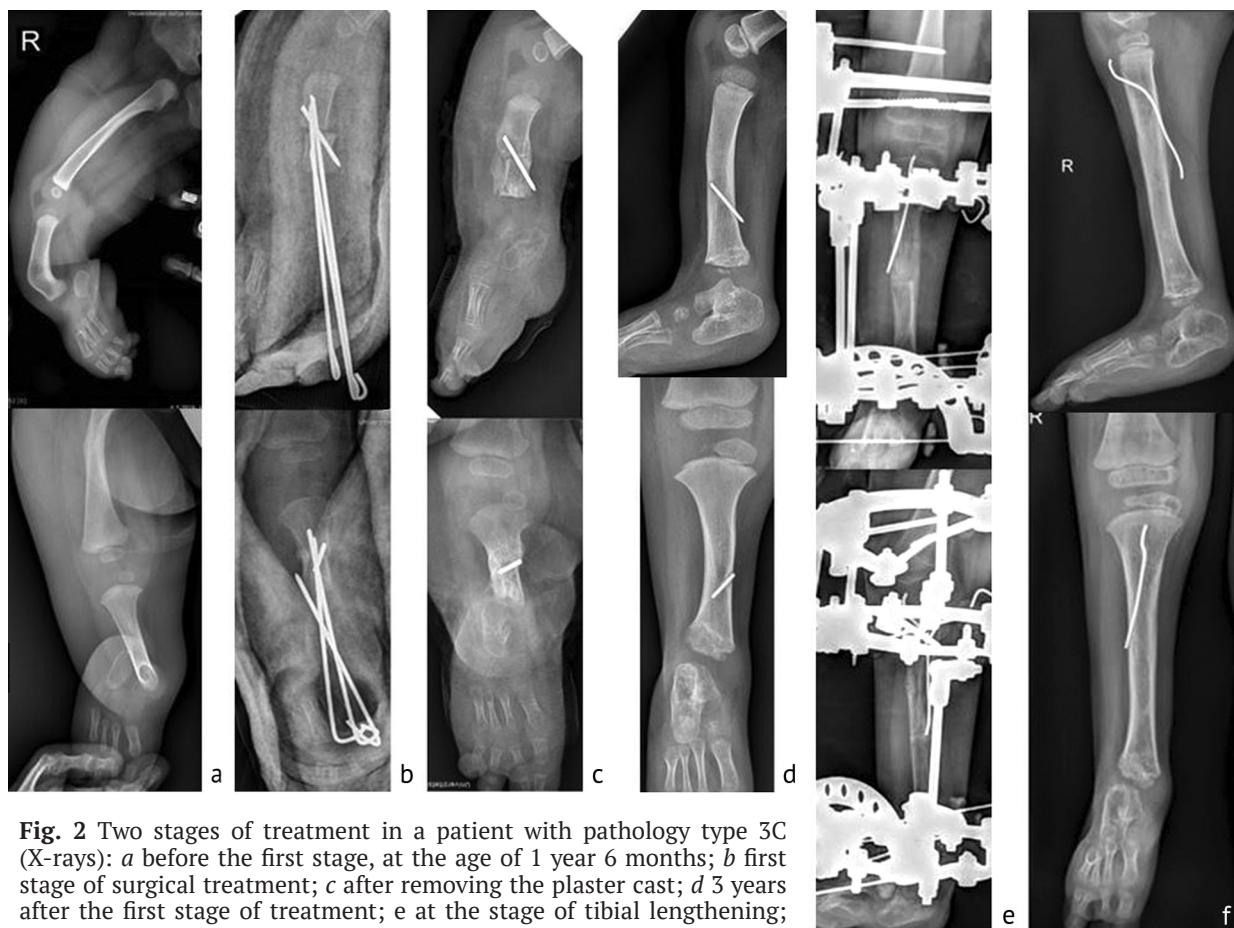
Two stages of treatment in a patient with pathology type 3C (X-rays): *a* before the first stage, at the age of 1 year 6 months; *b* first stage of surgical treatment; *c* after removing the plaster cast; *d* 3 years after the first stage of treatment; *e* at the stage of tibial lengthening; *f* one year after tibial lengthening
